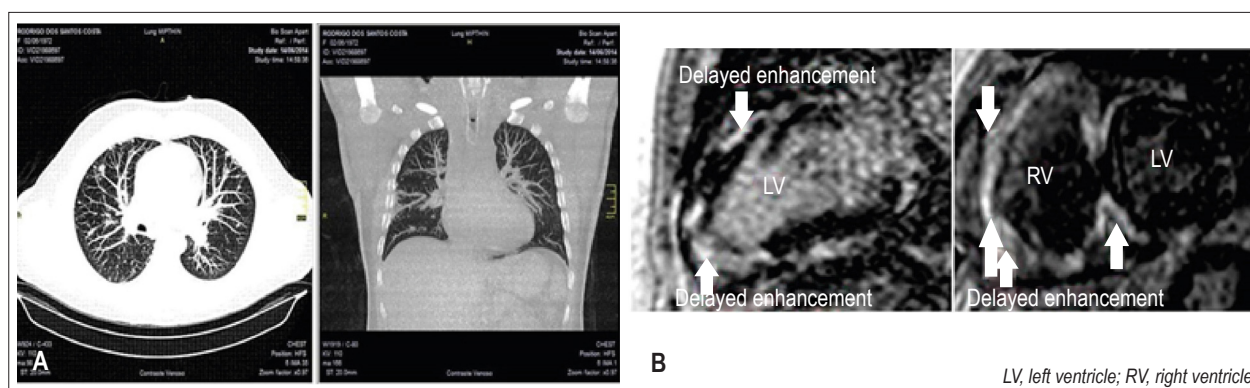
(A) Chest computed tomography image showing multiple lymph nodes, peri-lymphatic and mediastinal nodules, and peri-bronchial interstitial thickening. (B) Delayed enhancement diffusely affecting the right ventricle and several segments of the left ventricle in addition to significant septal involvement.
